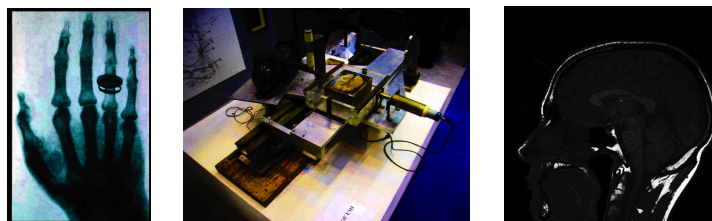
From left to right: The first X-ray image, taken by Roentgen in 1896; The first CT scanner prototype designed by Hounsfield; Sagittal MR image of the brain.
